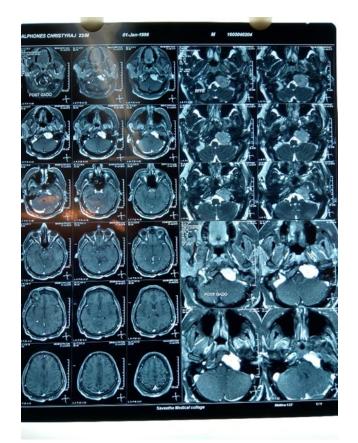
MRI Brain of the patient
